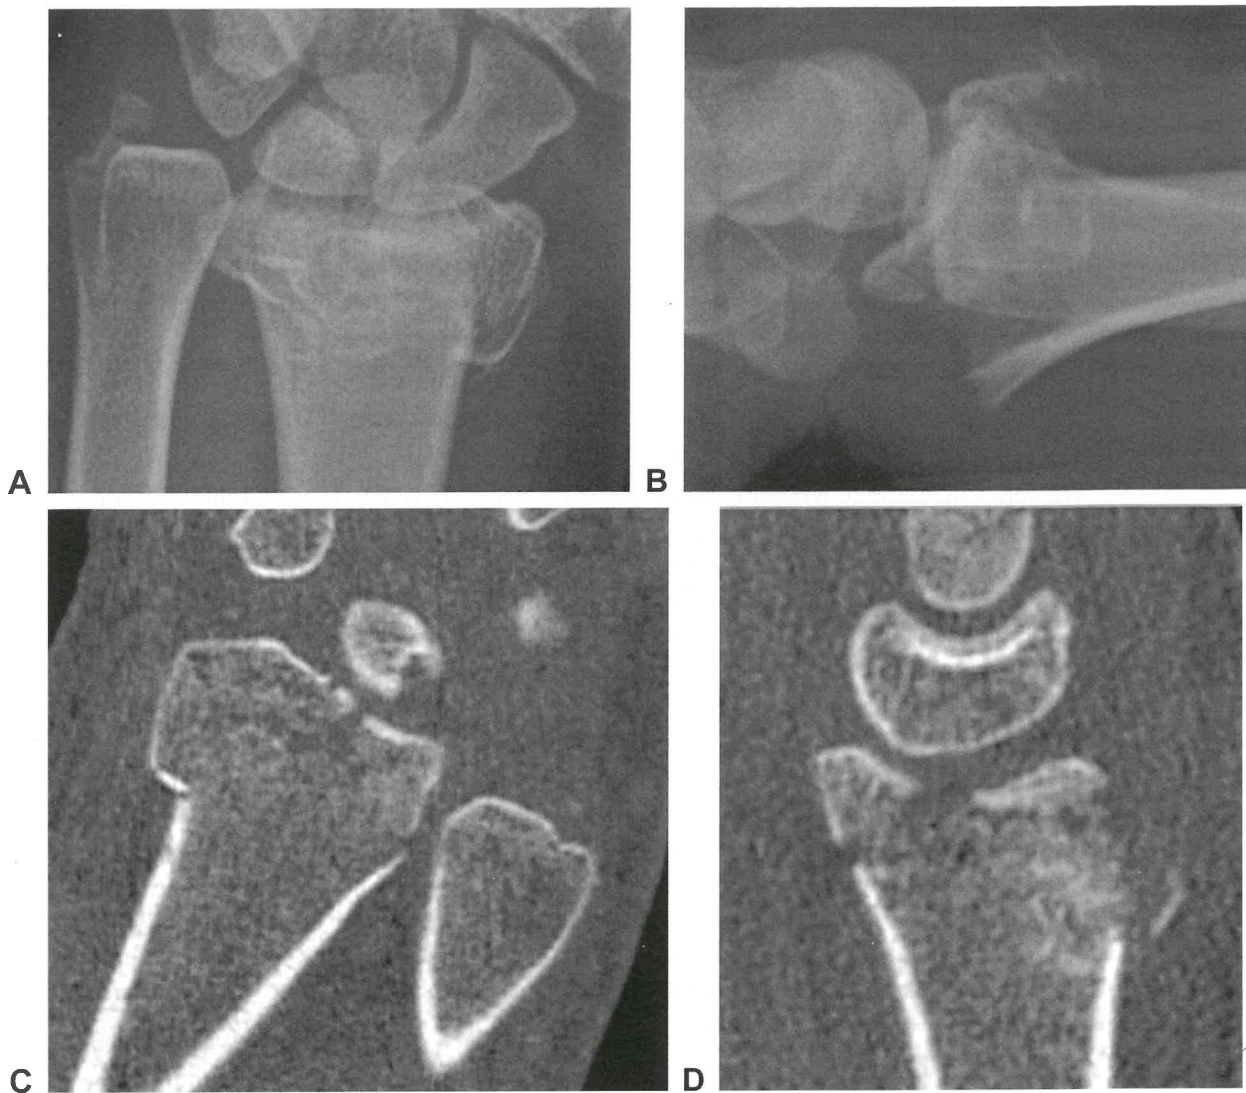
The injury radiographs A, B and computed tomographic images C, D show comminution and a distal volar ulnar fragment.
